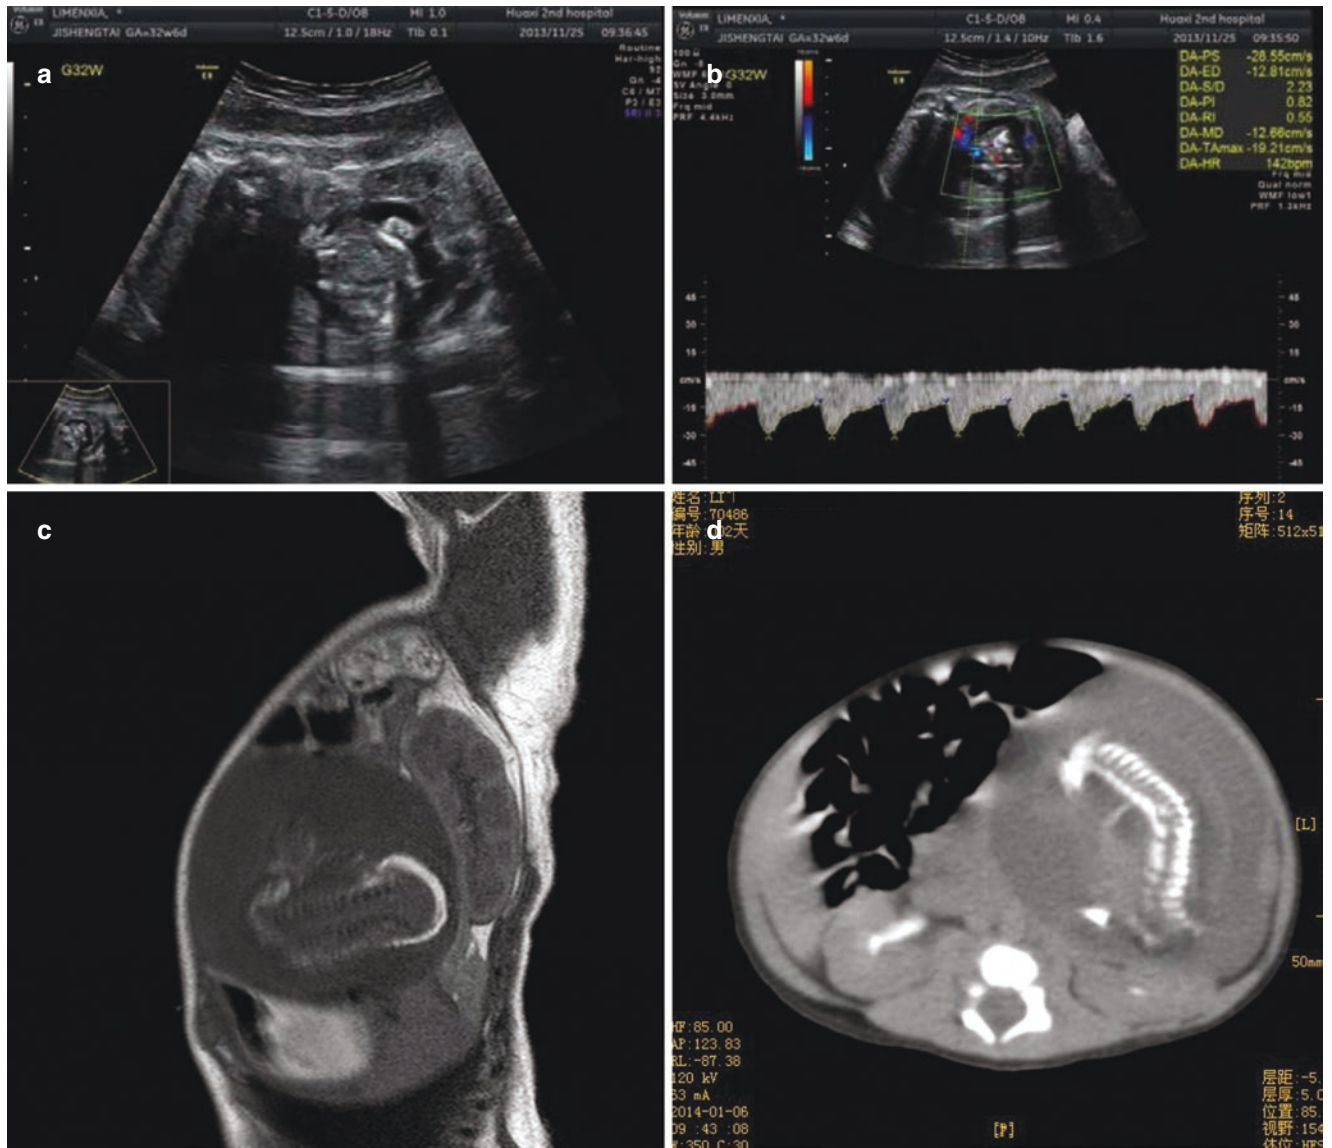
Fetus in fetu. (a, b). Prenatal ultrasound images; (c). Prenatal MRI image; (d). Postpartum CT image
